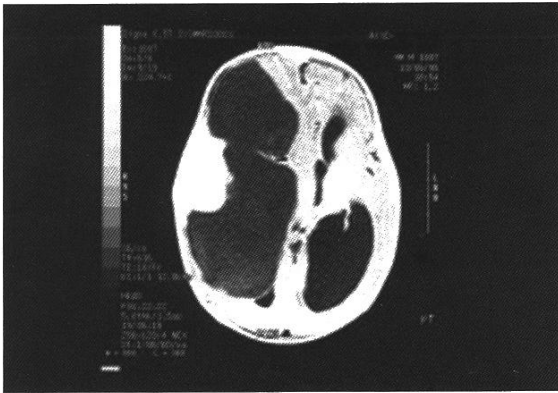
T-1-weighted MR image showing a right cystic mass with temporal mural nodule producing obliteration of the lateral ventricle.
